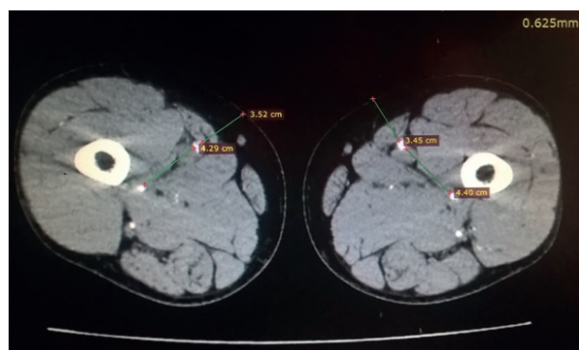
CT angiogram, transverse section at the level of the upper third of the thigh
